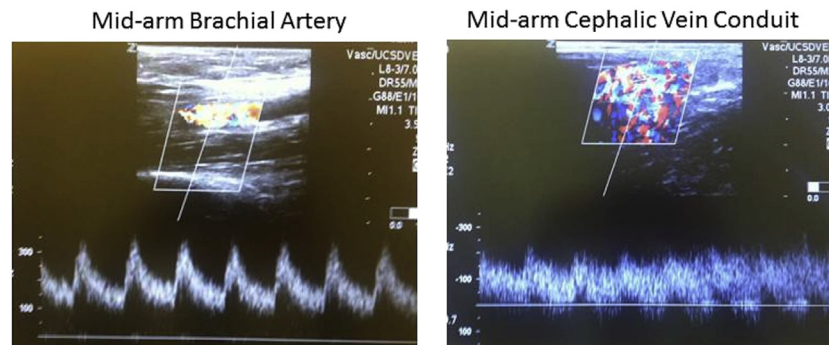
Pulsed Doppler velocity spectra recorded from the midarm brachial artery and cephalic vein conduit of a brachial-cephalic dialysis access fistula. Note, there is a less disturbed flow pattern in the brachial artery compared with spectral broadening of flow turbulence in the vein conduit.
